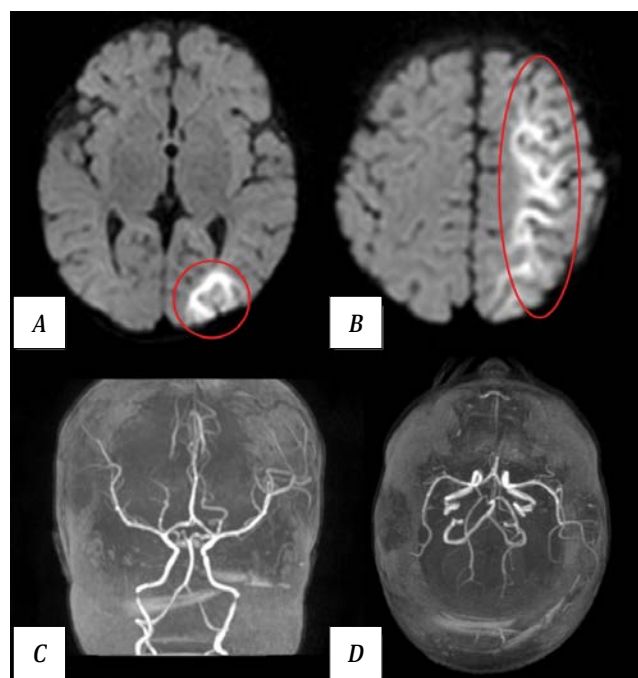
Results of patient T. MRI on day 2 postoperatively. A, B – brain MRI. Diffusion-weighted imaging (DWI), axial view. MRI findings of a watershed infarction in the left hemisphere (within the red oval). C, D – MR angiography, 3D reconstruction. Blood flow in the intracranial arteries of the head is intact.
